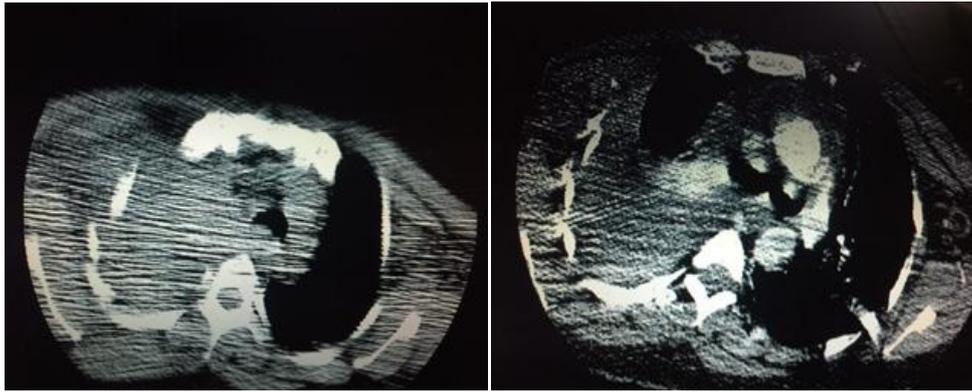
Massive hemothorax in spiral chest CT scan.
